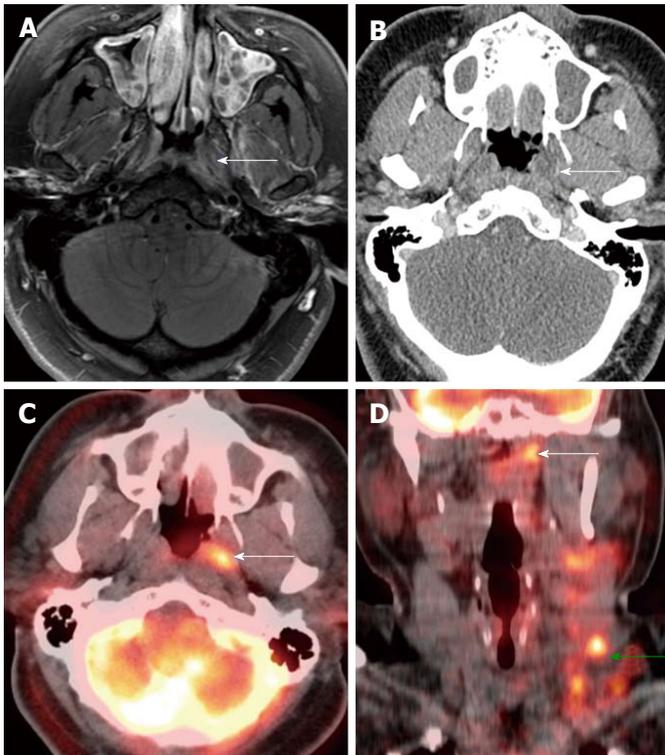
Positron emission tomography/computed tomography for detection of small submucosal nasopharyngeal carcinoma when computed tomography and magnetic resonance imaging are unrevealing in a patient presenting with metastatic cervical lymphadenopathy. Endoscopy was unremarkable. There was slight enhancement in the left side of the nasopharynx (white arrows) seen on magnetic resonance imaging (A) without abnormality on computed tomography (CT) (B). Positron emission tomography/CT (PET/CT) (C and D) revealed a focal hypermetabolic region in the left side of the nasopharynx (white arrows), suspicious for a submucosal tumor. Hypermetabolic left-sided cervical lymphadenopathy was also noted (green arrow). Biopsy revealed squamous cell carcinoma at the site of hypermetabolic activity in the left nasopharynx directed by PET/CT.
